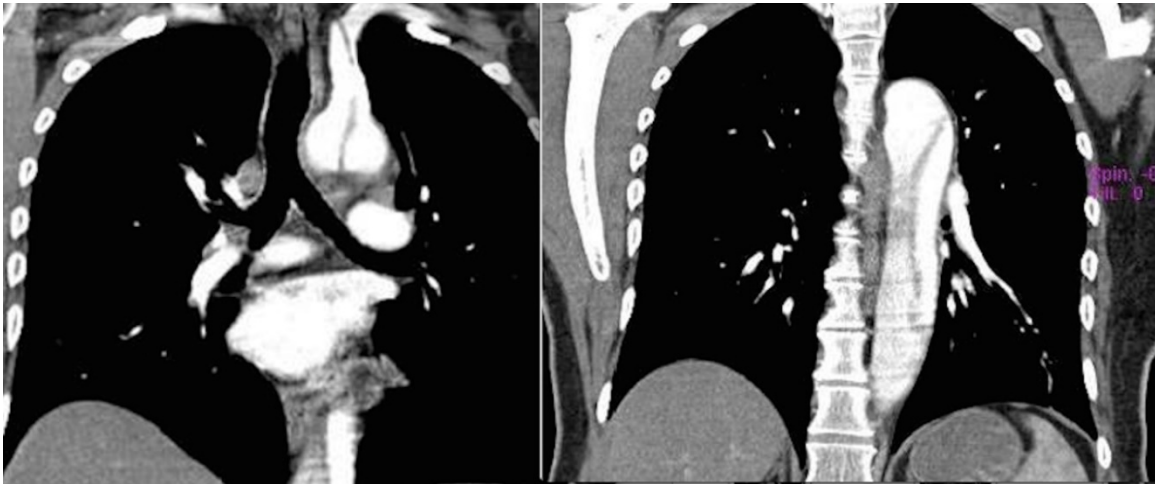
Type III aortic dissection. On CTA images, there is dissection extends from subclavian artery to diaphragm
